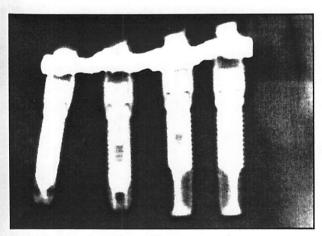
Postoperative radiographic appearance demonstrates bone scalloping and the preservation of the interimplant bone crest.
